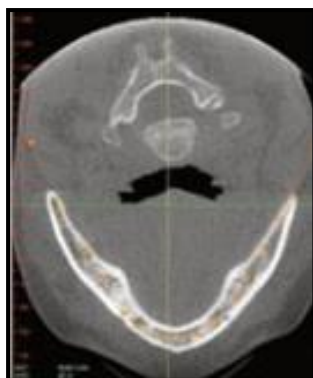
CBCT provides a highly sophisticated format for precisely defining the jaw structure and locating critical anatomic structures. CBCT in conjunction with software that renders the most real and accurate information, provide the most precise radiographic modality currently available for the evaluation of patients for mandibular implant over denture
